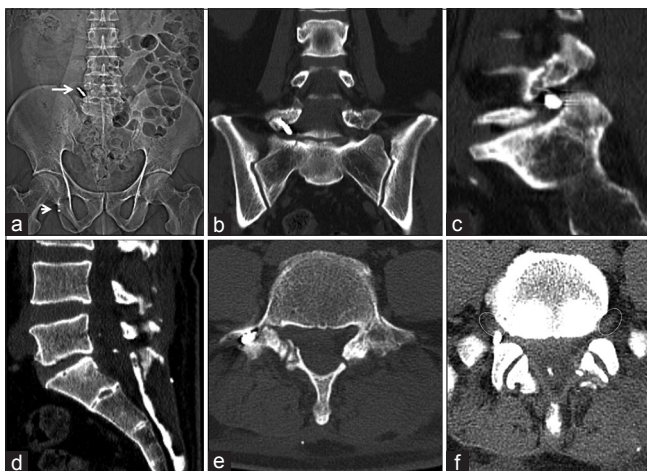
(a) Computed tomography topogram of the pelvis showing missile fragment in the right paravertebral region (long arrow), another small metal fragment overlapping ischium. (b and c) Coronal and sagittal reformatted computed tomography images showing missile fragment impregnated in the right L5 transverse process, projecting into L5-S1 neural foramina. (d) Sagittal reformatted image showing metallic fragment in thecal sac. (e) Fracture of bilateral L5 laminae. (f) Metal fragment compressing exiting right L5 nerve root. Corresponding normal left L5 nerve root shown in circle
